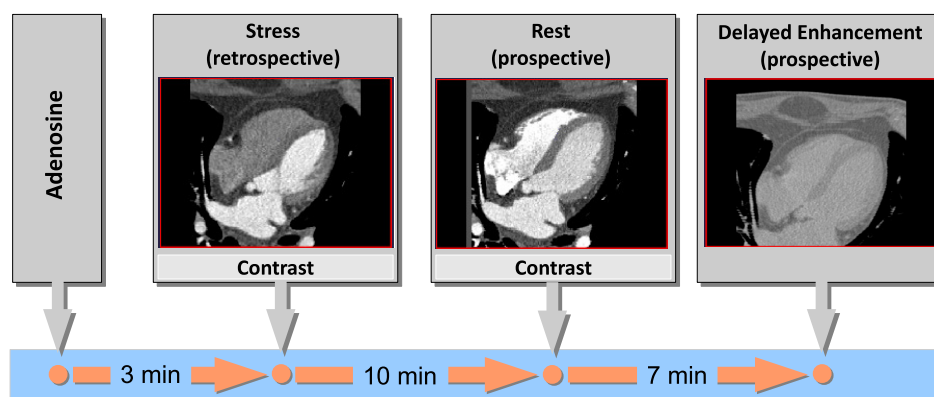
CT perfusion protocol, possibly including additional scan for delayed enhancement assessment.
